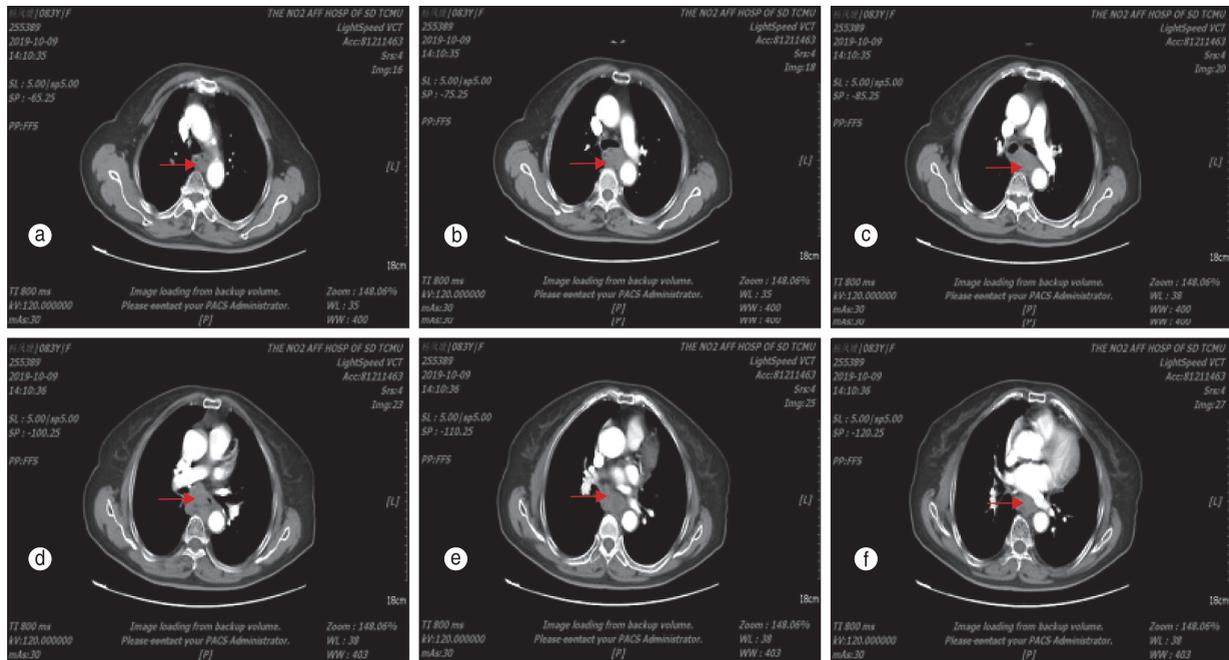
CT enhancement of chest + upper abdomen on December 9, 2019 shown: esophagel occupying lesions, the lumen was significantly narrow and mediastinal lymph node enlargement (the red arrow shows); pleural effusion on the right side (small amount)
